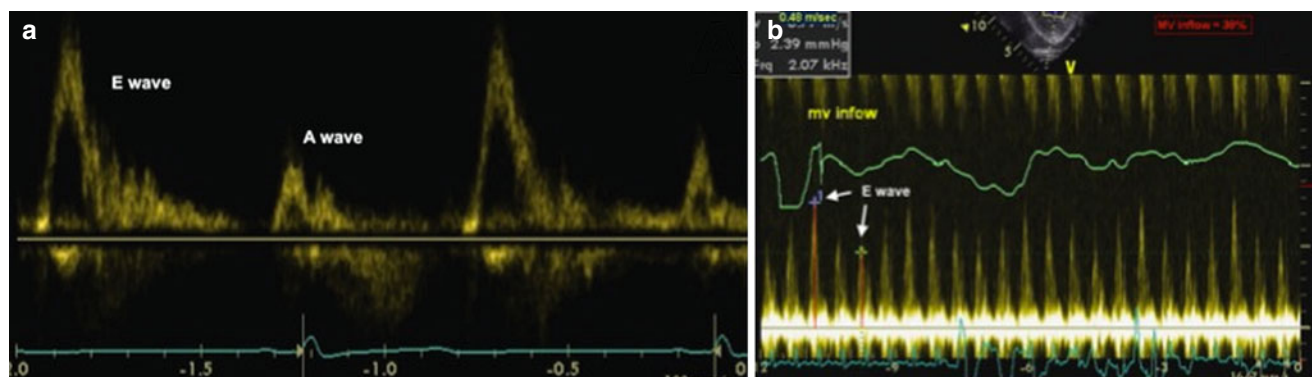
Mitral valve inflow Doppler. (a) Normal mitral valve inflow Doppler. Note the consistency in the height of the E wave. (b) Mitral inflow Doppler in cardiac tamponade. With increased sweep speed, one
